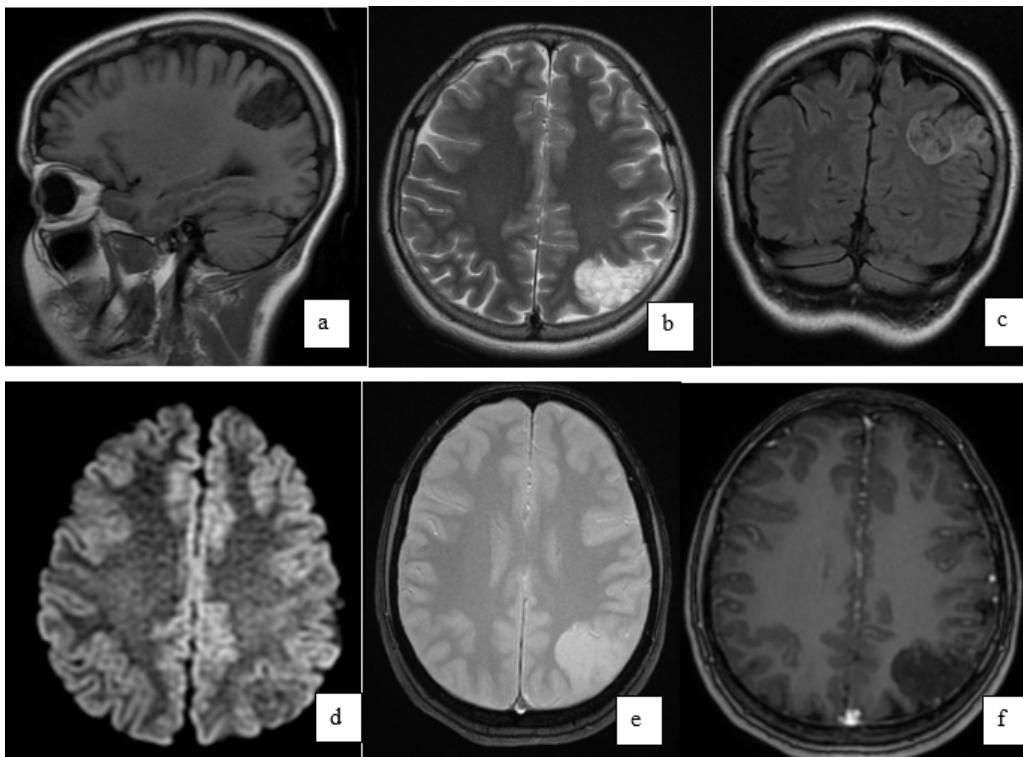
Cerebral MRI in sagittal and axial section showing a cortico-subcortical, left parietal area in T1 hypo-signal (a), in T2 hyper signal (b), with no peri-lesional oedema effect, nor mass effect with the presence of a ring in hyper signal on the Flair coronal sequence (c). On the diffusion sequence, the latter is hypo-signal (d), with no visualization of calcification or stigmata of haemorrhage on the T2 gradient echo sequence (e).nor contrast on the 3D T1 sequence after injection of gadolinium
